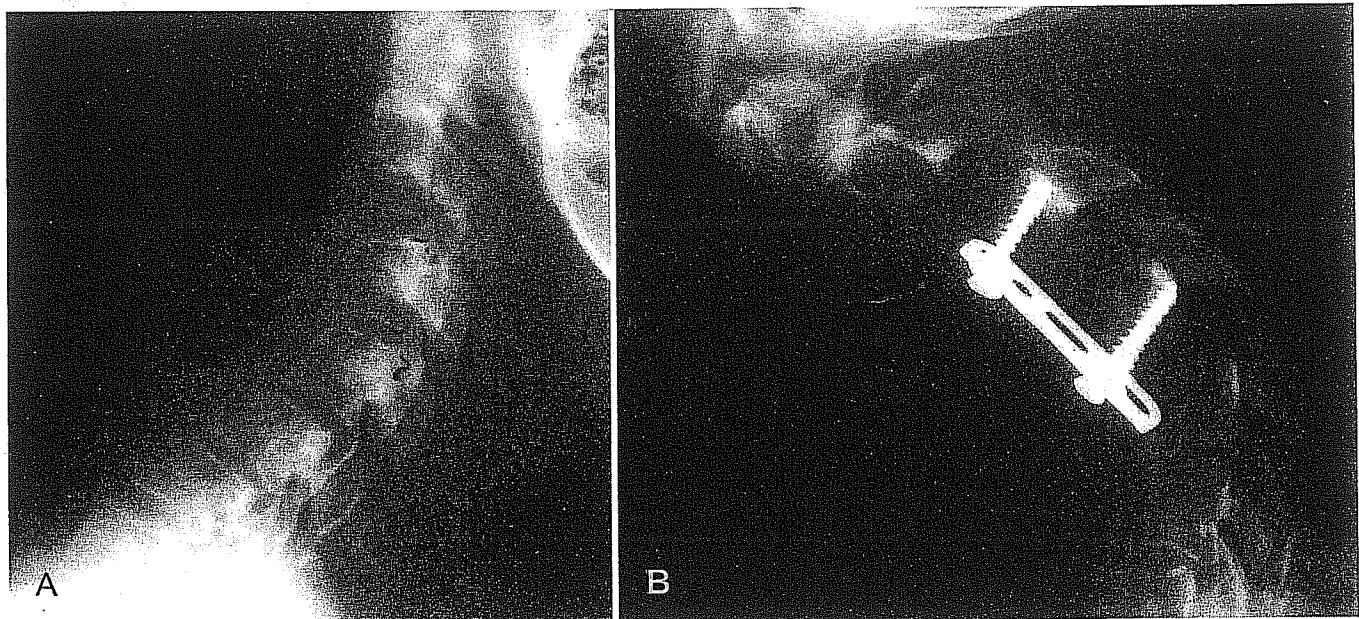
(A) Lateral cervical spine x-ray of a 35-year-old man who underwent C2–C5 laminectomy for resection of a cervical ependymoma. Despite total resection of the tumor, he developed progressive myelopathy several years after his initial operation as a result of subluxation at the C3–C4 level with spinal cord compression. (B)
